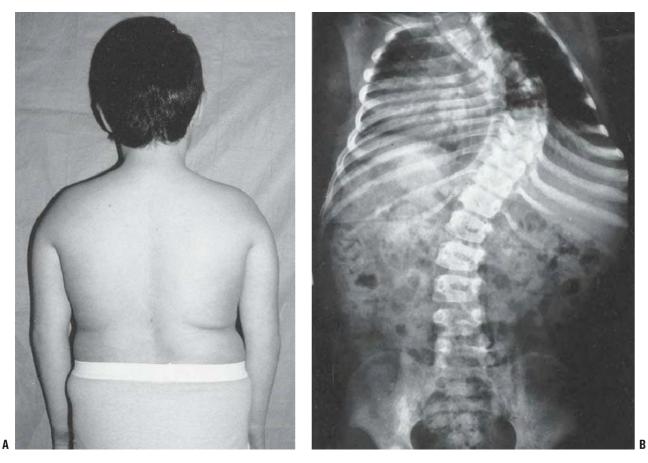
Prader-Willi syndrome in a 6-year-old patient. A: Scoliosis is difficult to detect because of the truncal obesity. B: The roentgenogram of this patient discloses a 50-degree thoracic curve. (B from Goldberg MJ. *The dysmorphic child: an orthopedic perspective*. New York, NY: Raven Press, 1987, with permission.)
